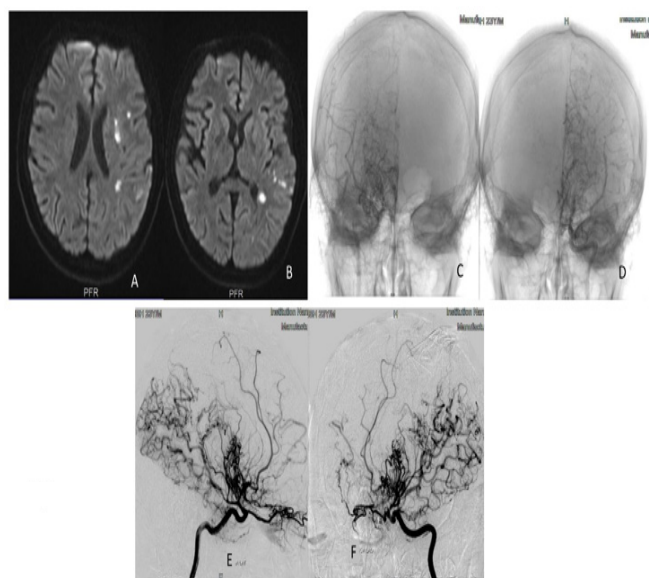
(A, B) MRI brain shows multifocal small areas of restricted diffusion in left parietal cortex and subcortical white matter, left centrum semi ovale, corona radiata and in the periventricular white matter adjacent to the temporal horn of the left lateral ventricle suggestive of acute infarcts along with multifocal chronic infarcts. (C-F) DSA shows bilateral supraclinoid ICA occlusion with rete/loco-regional collaterals supply reforming bilateral ACA, MCA territory with right PCA occlusion and loco-regional collaterals in posterior circulation reforming PCA territory suggestive of Moya Moya like phenomenon, Suzuki grade IV
